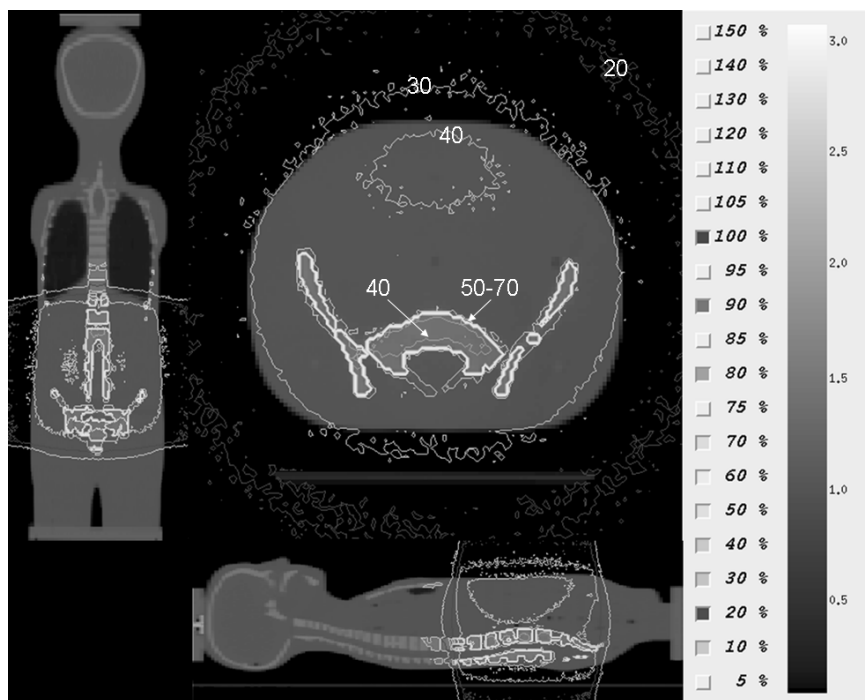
Abdominal/pelvis dose distributions of the pediatric CBCT scan. Axial, coronal, and sagittal views are presented with percent dose level and density bar ( $\text{g cm}^{-3}$ ).
